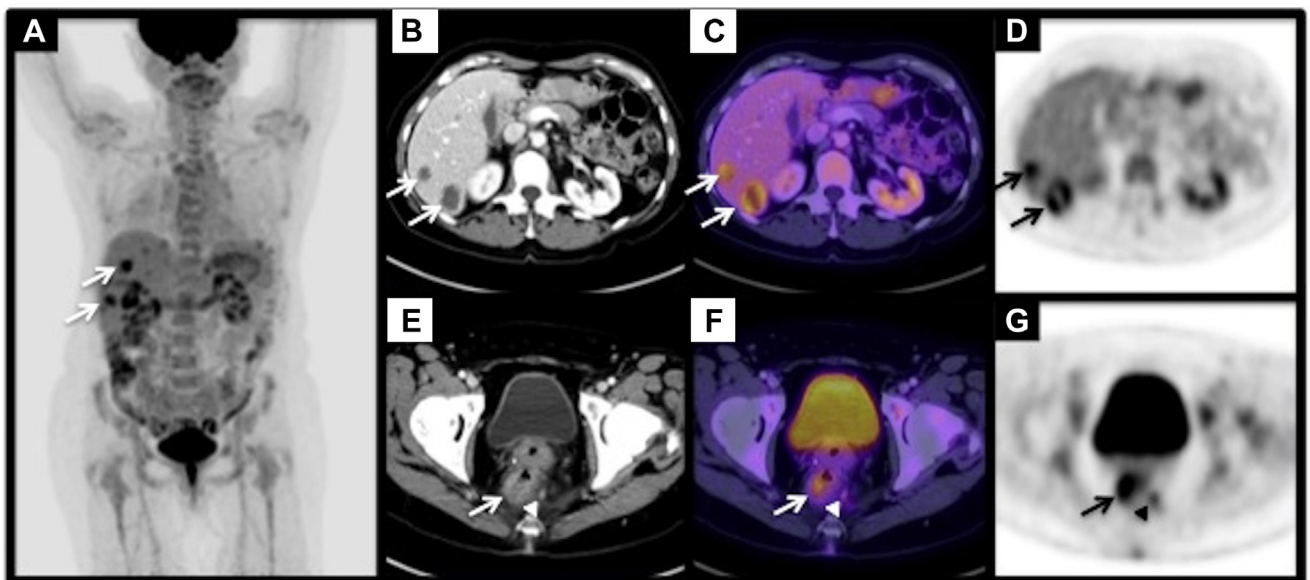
A 60-year-old woman with follicular lymphoma. 3D-MIP image from a 3-month ^{18}F -FDG PET/CT follow-up after chemotherapy (A) demonstrates marked improvement of diffuse hypermetabolic lymphadenopathy. However, PET/CT 3D-MIP (A) and representative axial CT (B), PET-CT fused (C) and attenuation-corrected PET images (D) of the upper abdomen show interval increase in size and metabolic activity of the subtle liver lesion noted retrospectively on the baseline scan and interval development of multiple new hypermetabolic intrahepatic lesions (arrows). In addition, axial CT (E), PET-CT fused (F), and attenuation-corrected PET images (G) of the pelvis demonstrate a new, subtle area of rectal wall thickening (arrow) and a mildly prominent perirectal lymph node (arrowhead).
